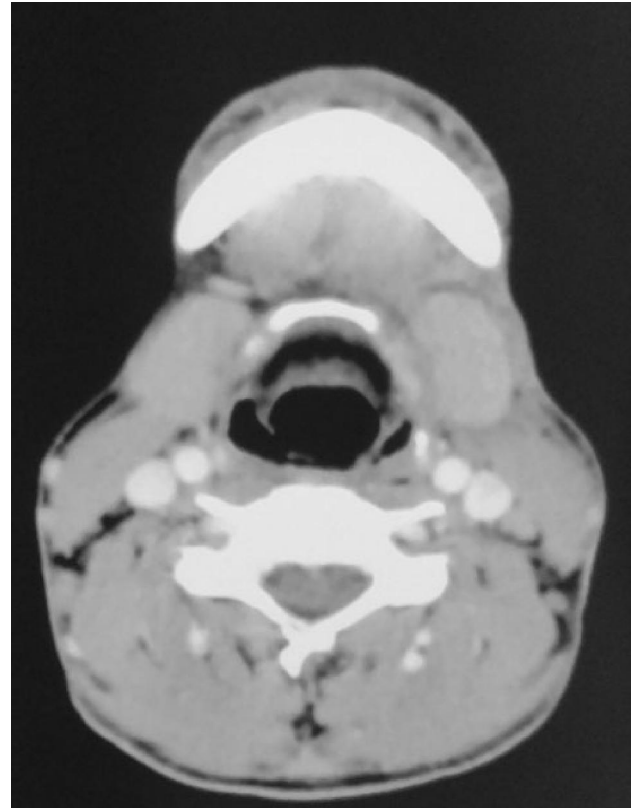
Post Treatment follow up CT scan showing complete resolution of laryngeal mass.
